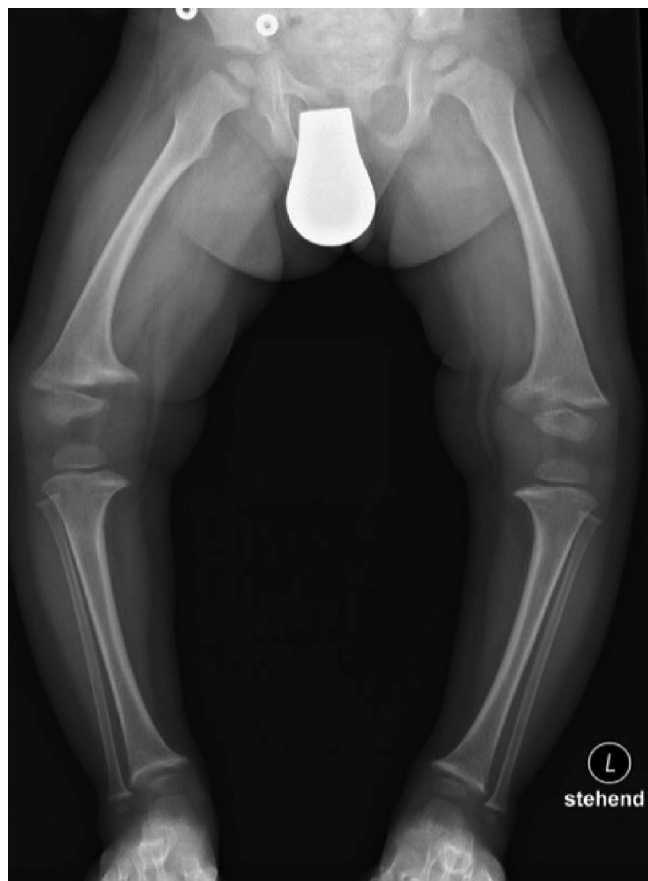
Active rachitic bone disease on X-ray of both legs. Note reduced bone density, widening of the metaphyses, and fraying of the epiphyses
